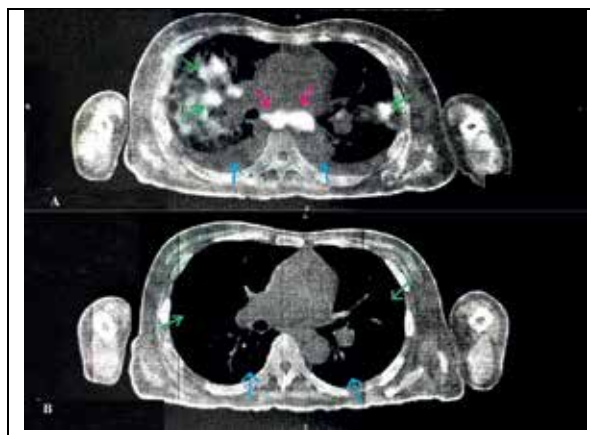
(A) Pre-chemotherapy positron emission tomography/computed tomography scan showing multiple hypermetabolic lesions in lungs (green arrows), bilateral pleural effusion (blue arrows) and mediastinal lymphadenopathy (pink arrows); (B) Post-chemotherapy positron emission tomography/computed tomography scan showing reduced metabolic activity in previously noted areas (green arrows) with no evidence of pleural effusion (blue arrows).
